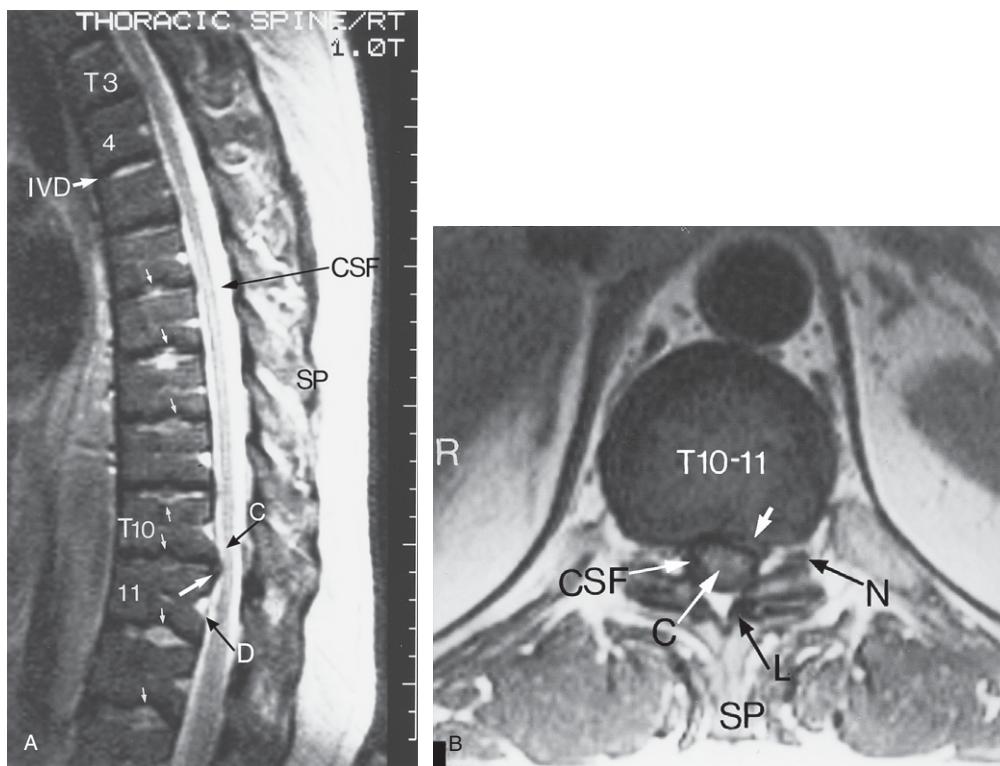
(A) MRI thoracic spine sagittal T2-weighted image which shows the Schmorl's nodes from T6 to T12 (small white arrows). Note the T10-11 disc protrusion compressing the anterior part of the dural tube (D) and apparently touching the spinal cord (C) which lies within the dural tube surrounded by cerebrospinal fluid (CSF) that is white on the T2-weighted MRI image. IVD = disc with normal hydration (as compared to the T3-4 disc that shows desiccation (blackening); SP = spinous process. The numerals 3, 4, 10 and 11 indicate thoracic vertebral bodies. (B) Thoracic spine MRI axial T1-weighted image through the T10-11 intervertebral disc showing the left sided disc protrusion (small white arrow) that impresses upon the dural tube with some distortion of the spinal cord (C) itself as it lies within the cerebrospinal fluid (CSF) that appears as a dark area around the cord on this T1-weighted image. L = ligamentum flavum; N = spinal ganglion within the intervertebral foramen; SP = spinous process.
